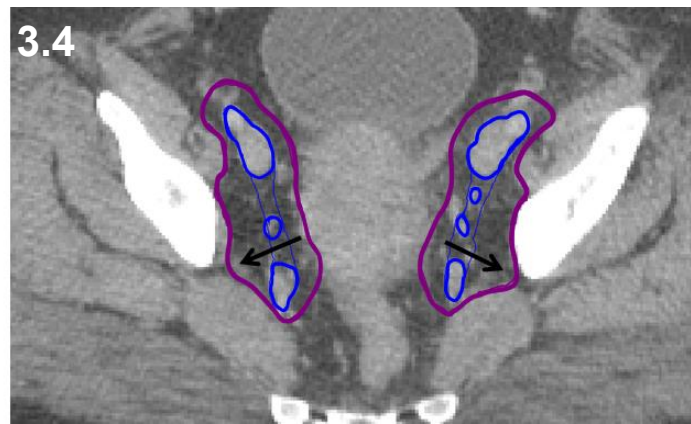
Transverse CT showing the CTV2 outline extending fully to the pelvic sidewall (in direction of arrows).
